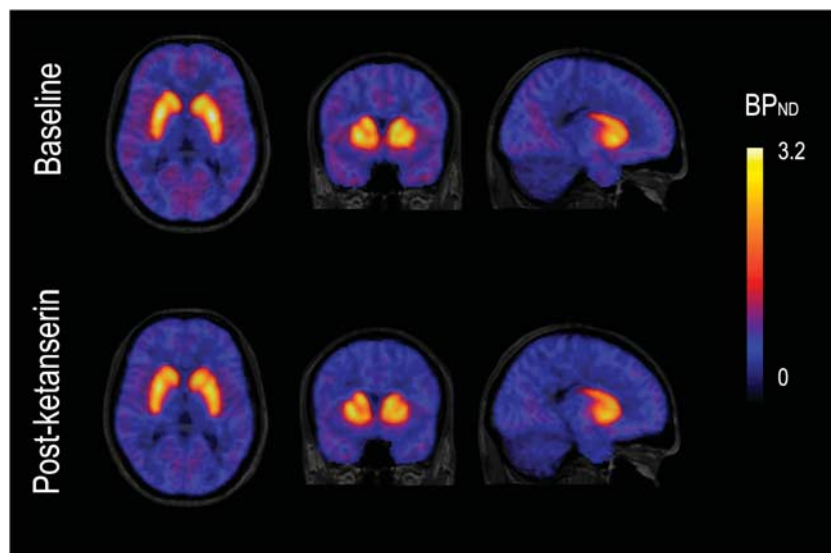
Co-registered MRI: $[^{11}\text{C}]\text{NNC112}$ PET BP_{ND} parametric images (mean from all subjects, $n = 6$), at baseline (top) and after ketanserin 0.15 mg/kg, i.v. (bottom). The decrease of $[^{11}\text{C}]\text{NNC112}$ signal in the cortical regions, without modification in the striatum, is appreciated.
